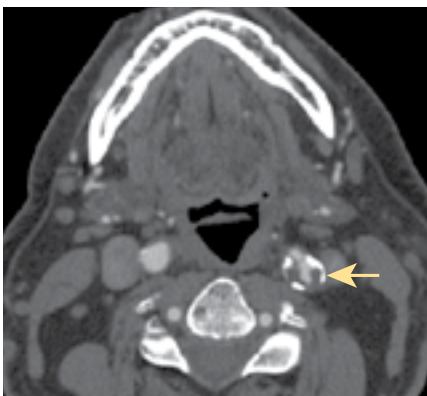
A CT scan slice through carotid artery with plaque shows white flecks of calcium are present (arrow) but there are larger, dark areas of “soft” plaque seen adjacent to and beneath the areas of calcium.
